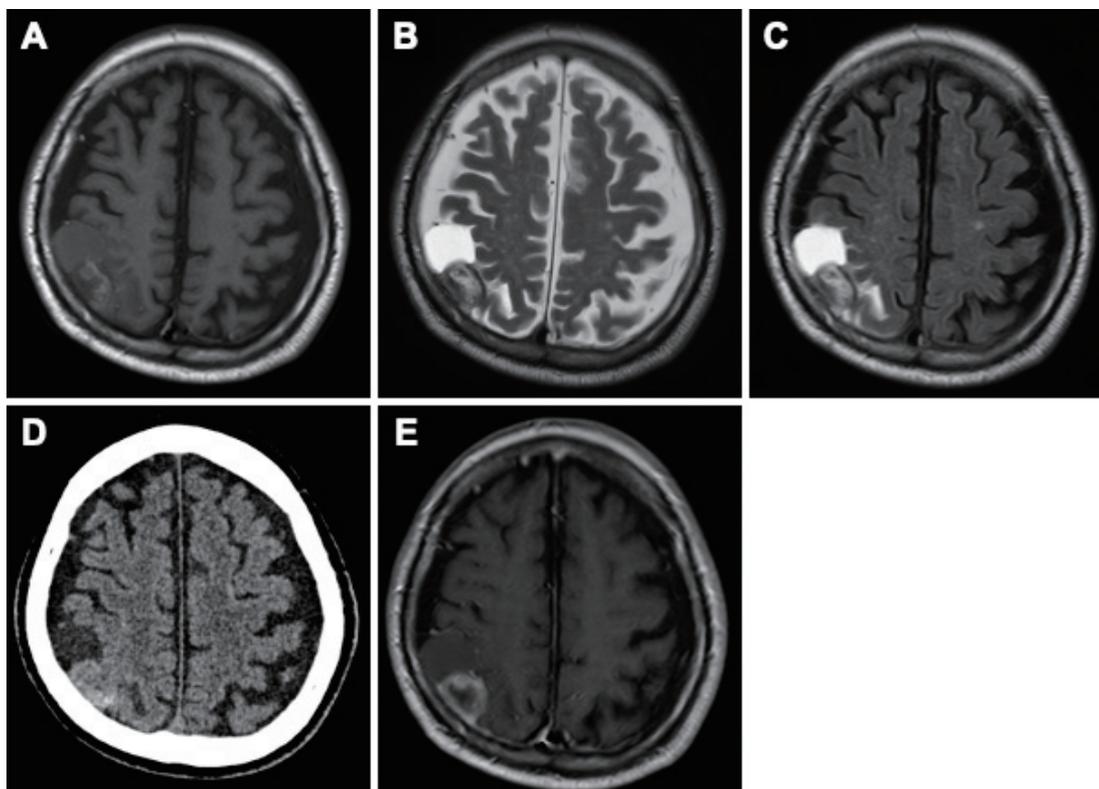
(A) T1-weighted MR image showing the heterogeneous hyperintense solid lesion and the isointense cystic lesion in the right parietal region. (B and C) T2-weighted (B) and FLAIR MR (C) images showing the heterogeneous hyperintense solid and the hyperintense cystic lesions. (D) Head CT showing no calcification in the mass. (E) Gadolinium contrast-enhanced, T1-weighted MR image showing the solid lesion with heterogeneous enhancement and the cystic lesion in the right parietal region. CT: Computed tomography; FLAIR: fluid-attenuated inversion recovery; MR: magnetic resonance
